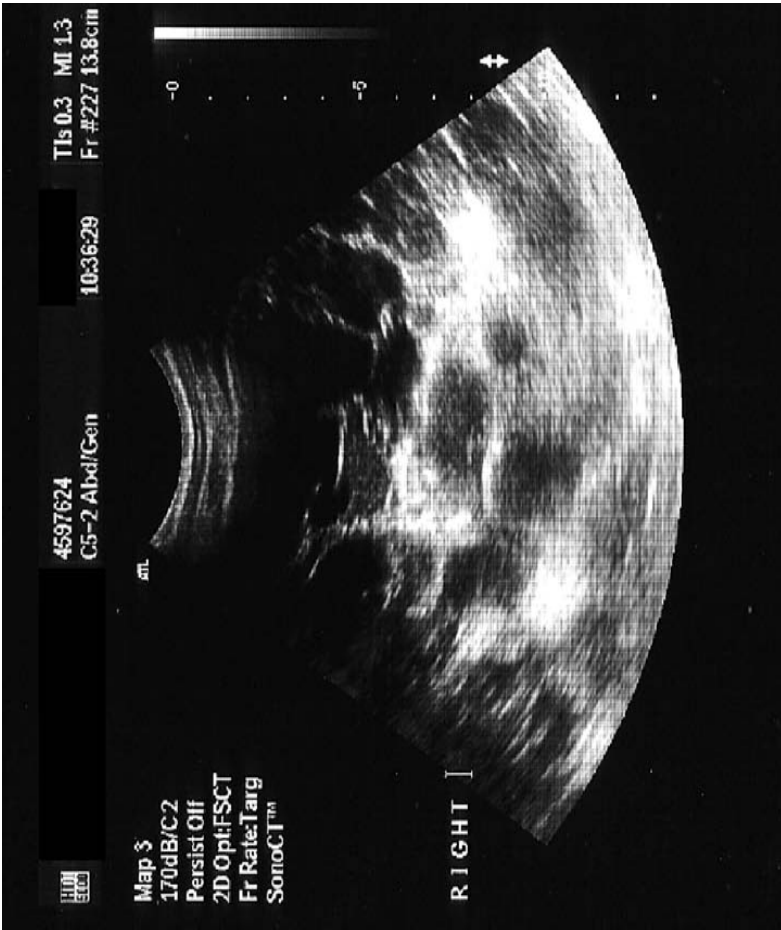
Ultrasound picture of large cyst in left kidney. Reproduced with permission of the patient and the radiologist.
